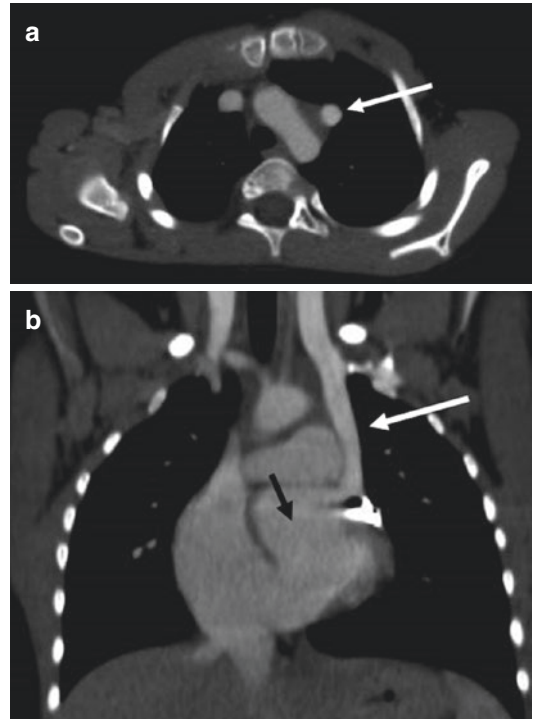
Totally unroofed coronary sinus and persistent left superior vena cava at CT angiography. (a) Axial and (b) coronal thin maximum intensity projection images demonstrate an absence of wall between the coronary sinus and the left atrium (*black arrow*), a persistent left superior vena cava (*white arrows*), a right superior vena cava, and an absence of left brachiocephalic vein. The orifice of the coronary sinus is enlarged
